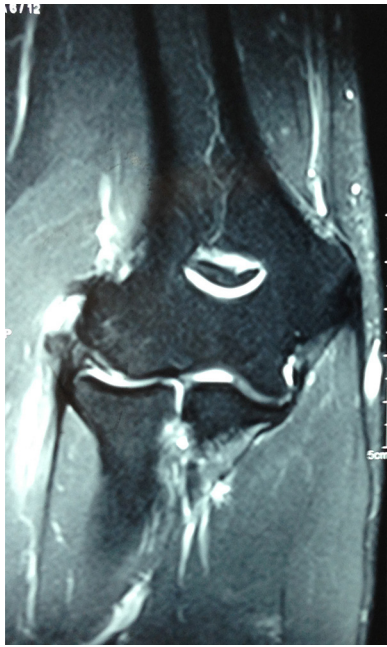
Magnetic resonance imaging of coronal section showing a lesion of the short radial extensor tendon.
